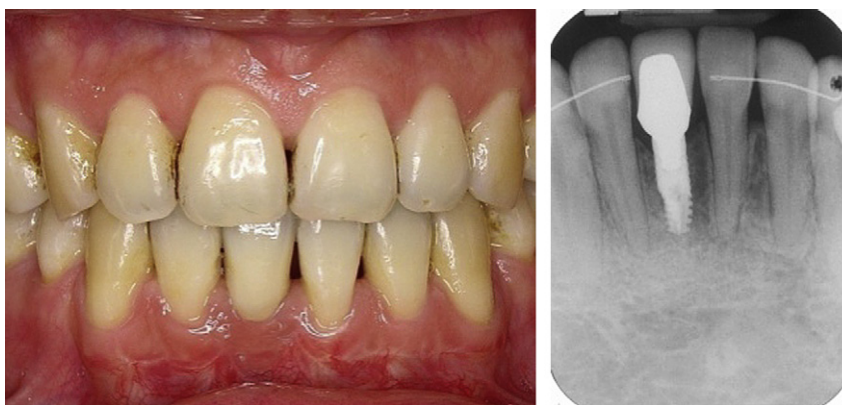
A zirconium abutment and an all-ceramic crown were delivered and cemented (left) and periapical film (right).
